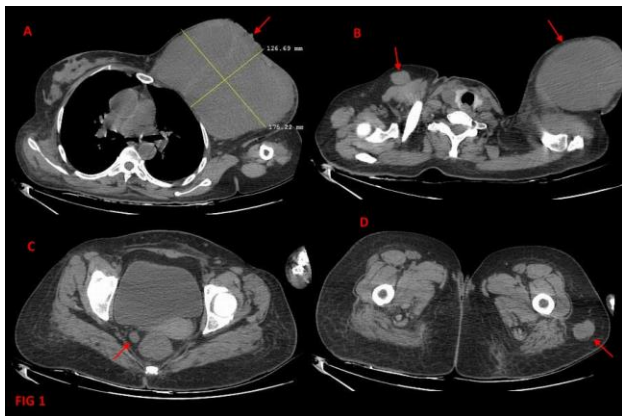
Axial non-contrast CT showing multiple low attenuating lesions in different regions (arrows) with attenuation lower than that of adjacent muscles. Due to high water content of the lesions; the largest one is noted in left breast. There is no intrathoracic extension. No foci of calcification noted.
